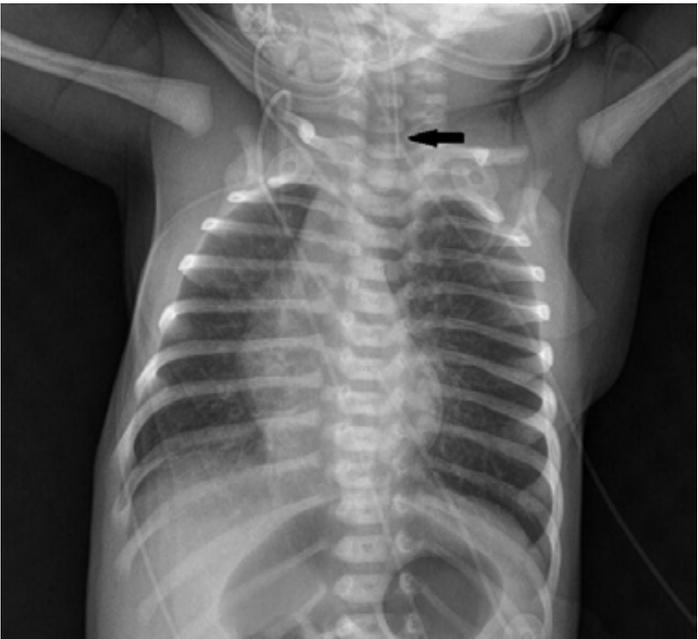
Chest and abdomen x-ray one view. Findings: OG is at the proximal esophageal pouch, suggesting esophageal atresia (arrow); the abdomen is distended, with air and fluid-filled, indicating a distal tracheoesophageal fistula.
